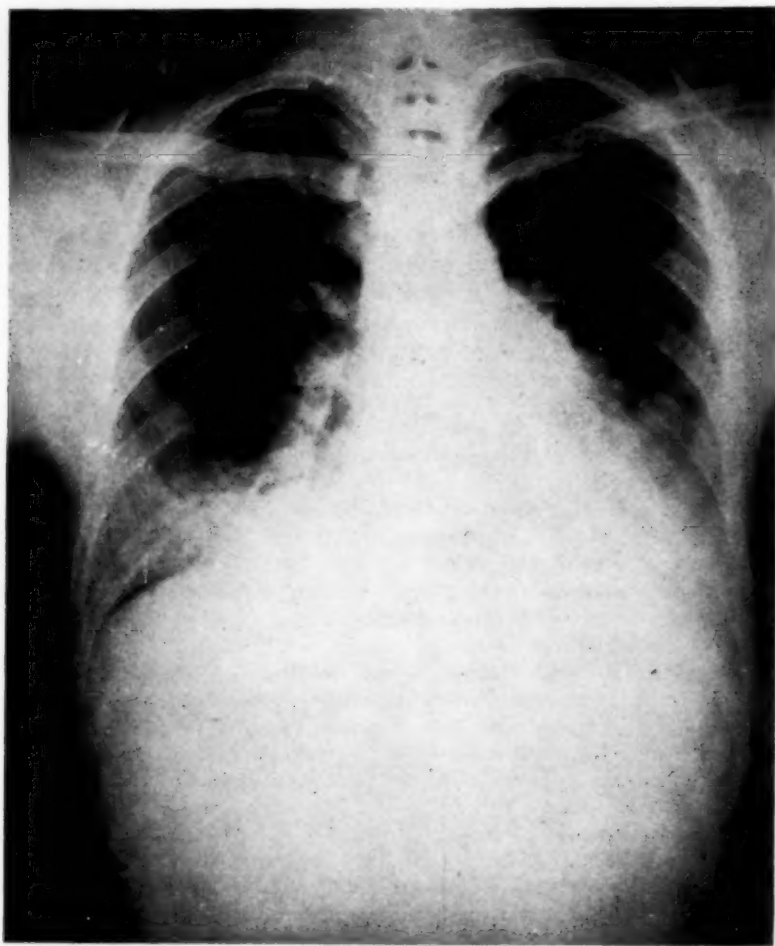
Roentgenogram of chest before treatment.
